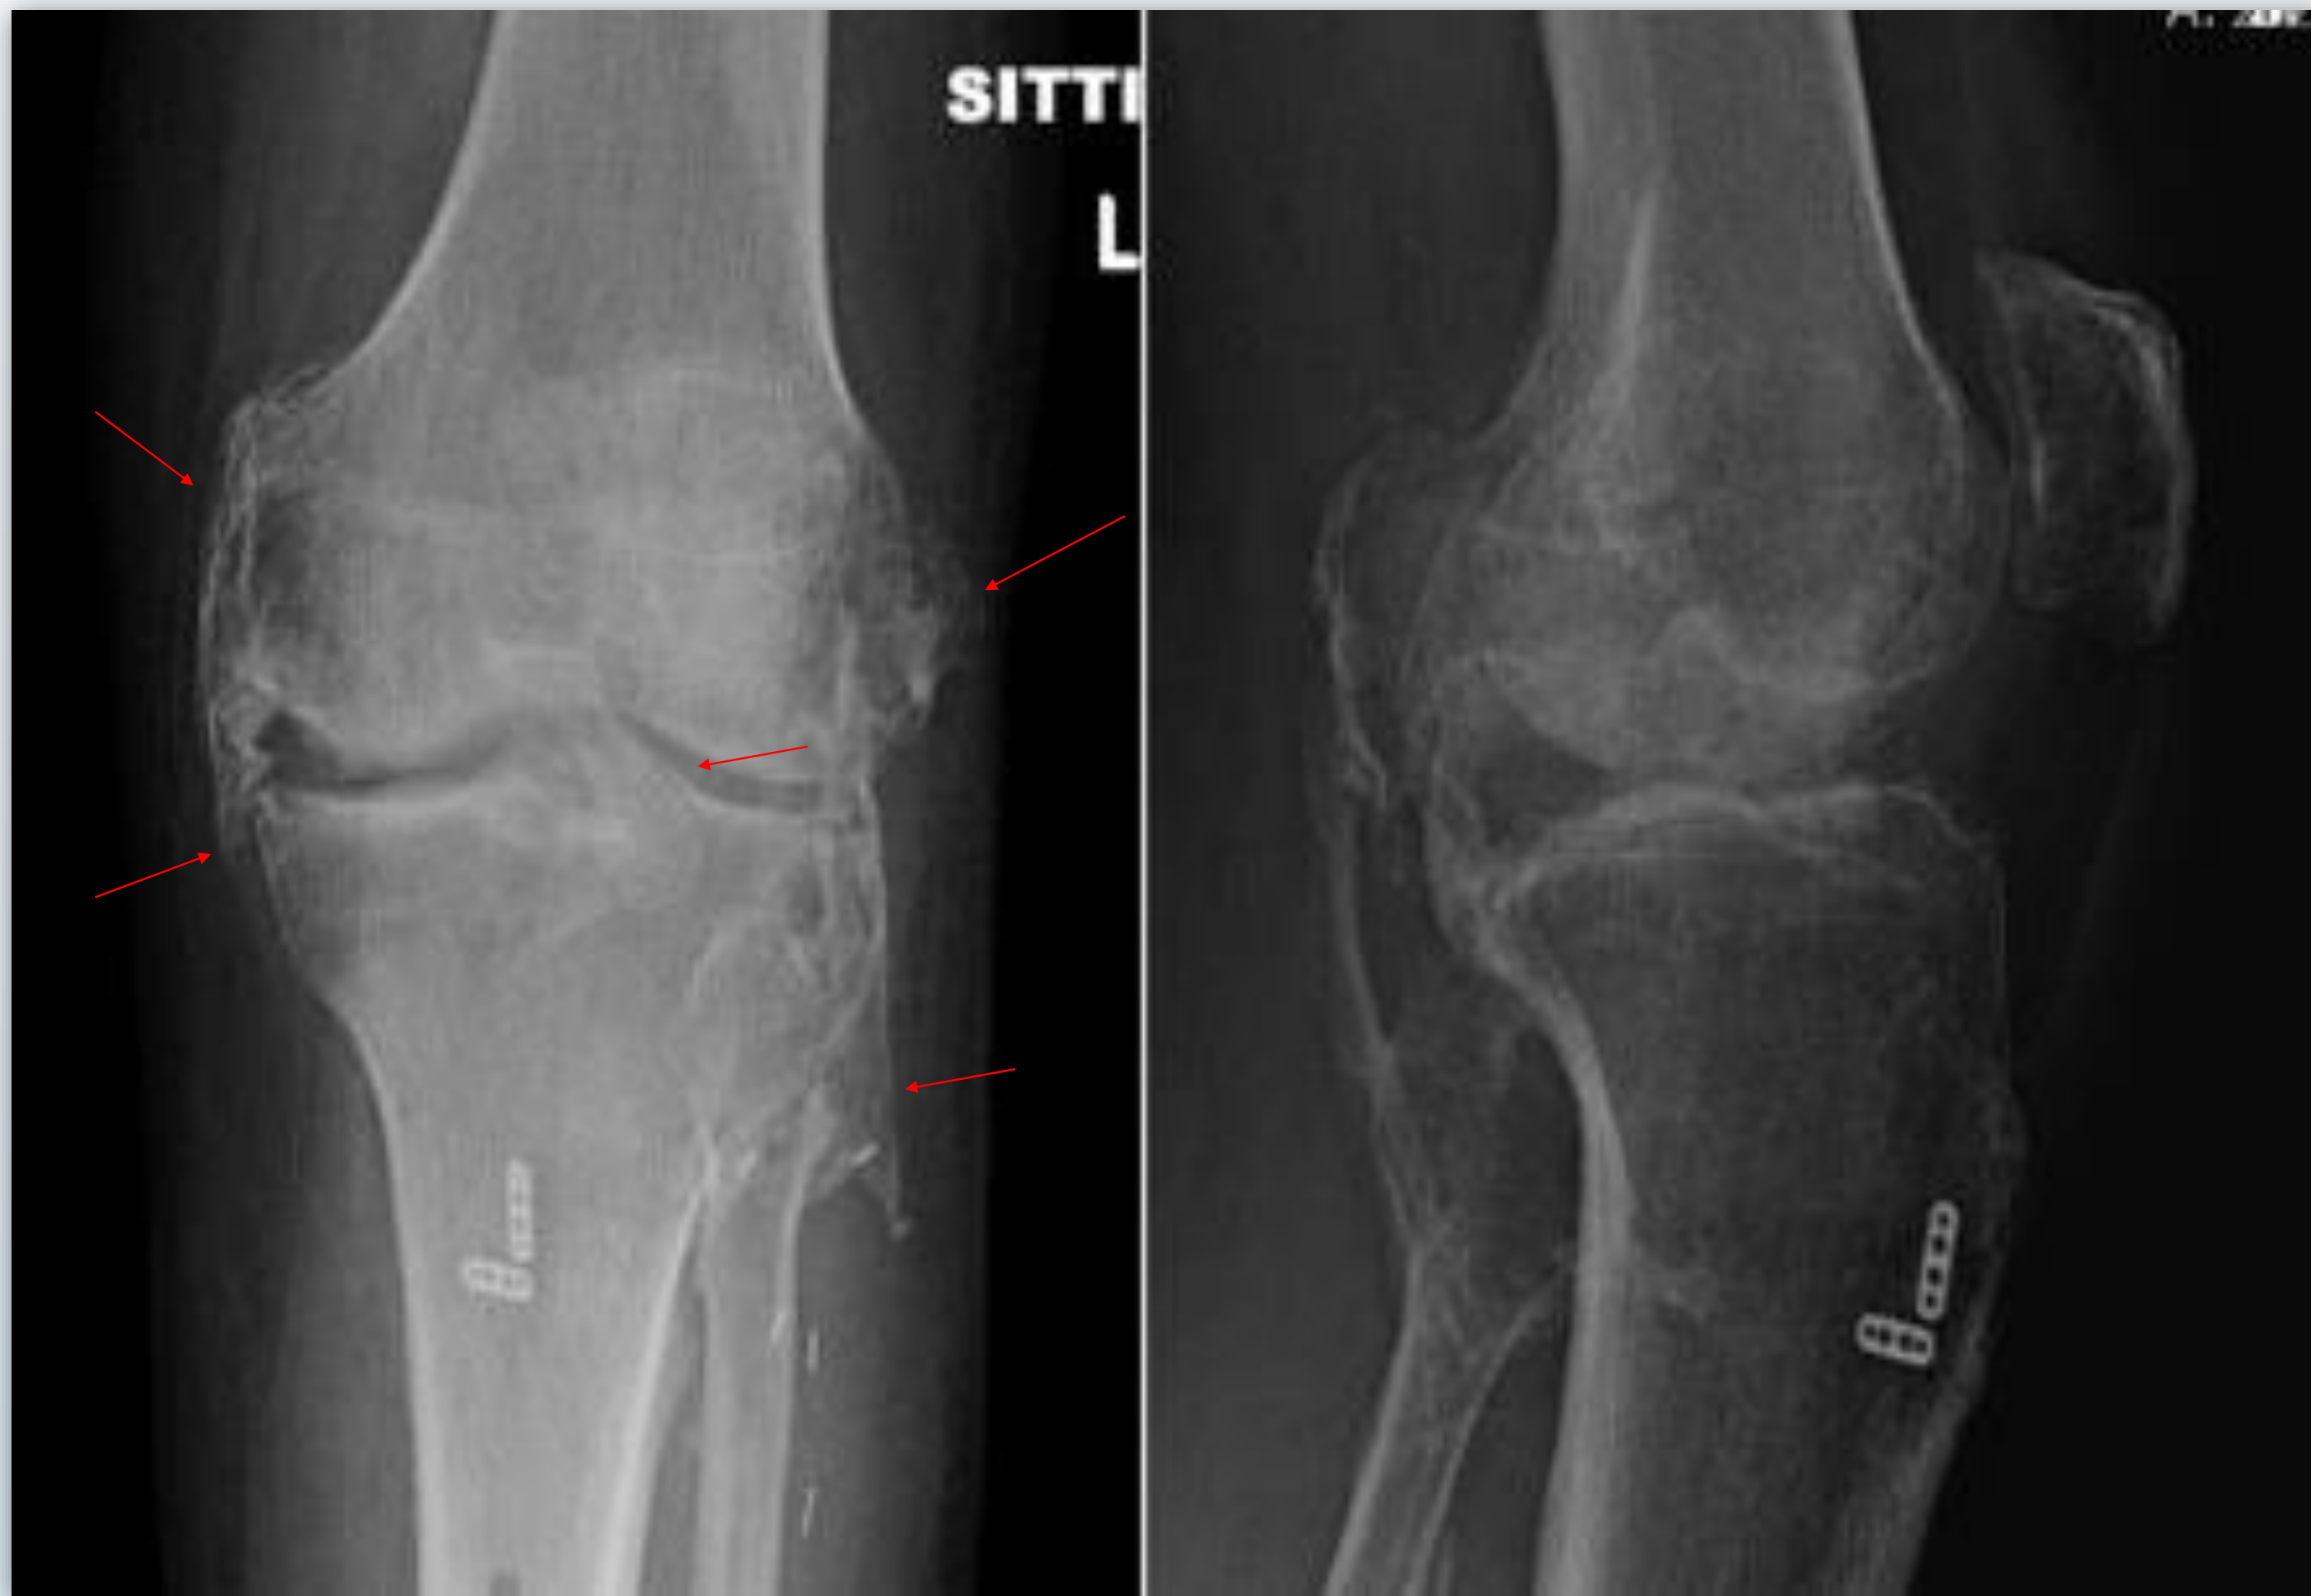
Heterotopic ossification on radiographs following a KD4 injury
